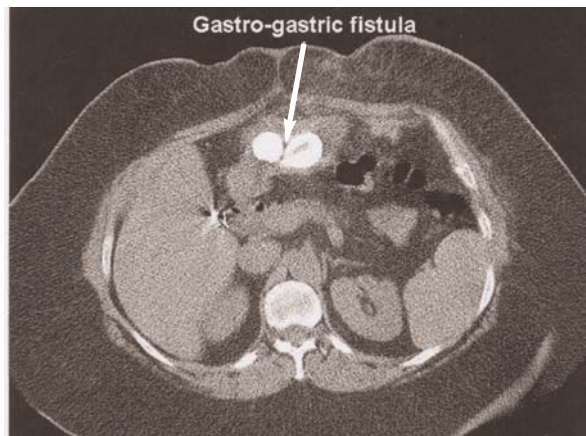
Preoperative abdominal CT scan. Arrow points to GGF.
